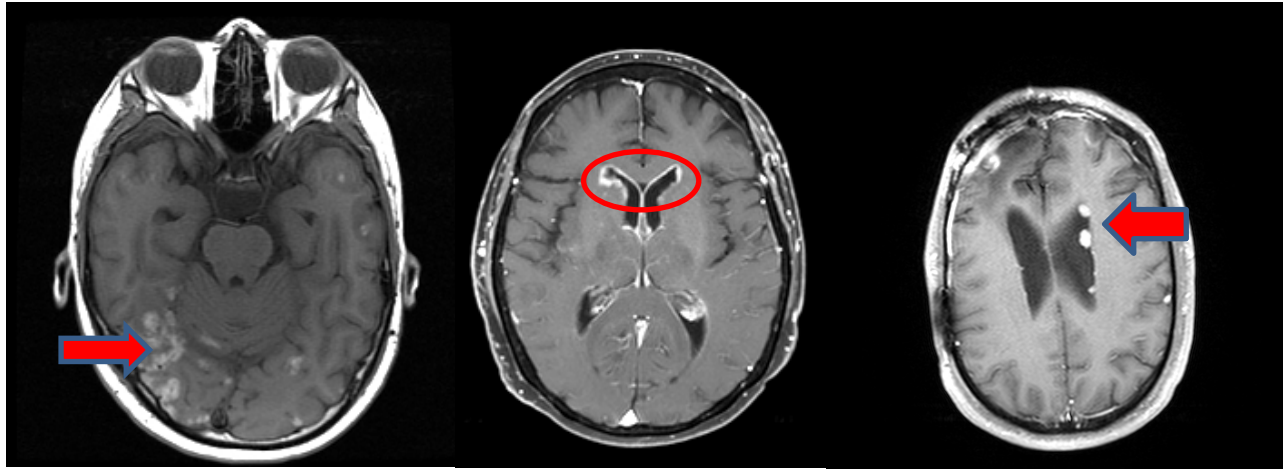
Radiographic findings of LMD: diffuse leptomeningeal enhancement, “zuckerguss” of the ventricle horns and nodular tumor foci within the ventricle
